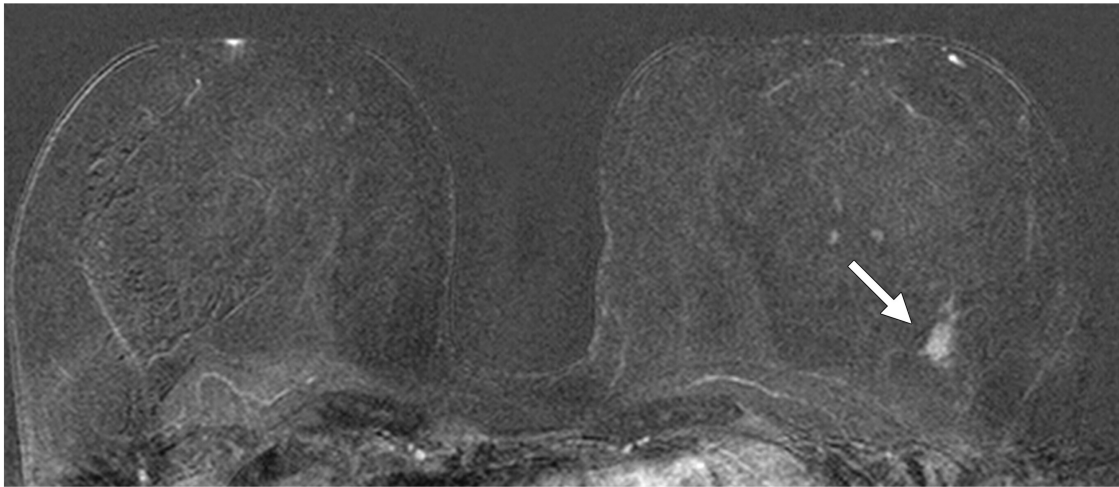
Example of a DCE-MRI image showing a suspicious enhancing mass in the left breast confirmed as invasive high-grade triple-negative cancer. Figure reproduced from Kuhl et al. [64] with permission from the Radiological Society for North America (permission conveyed through Copyright Clearance Center Inc.).
